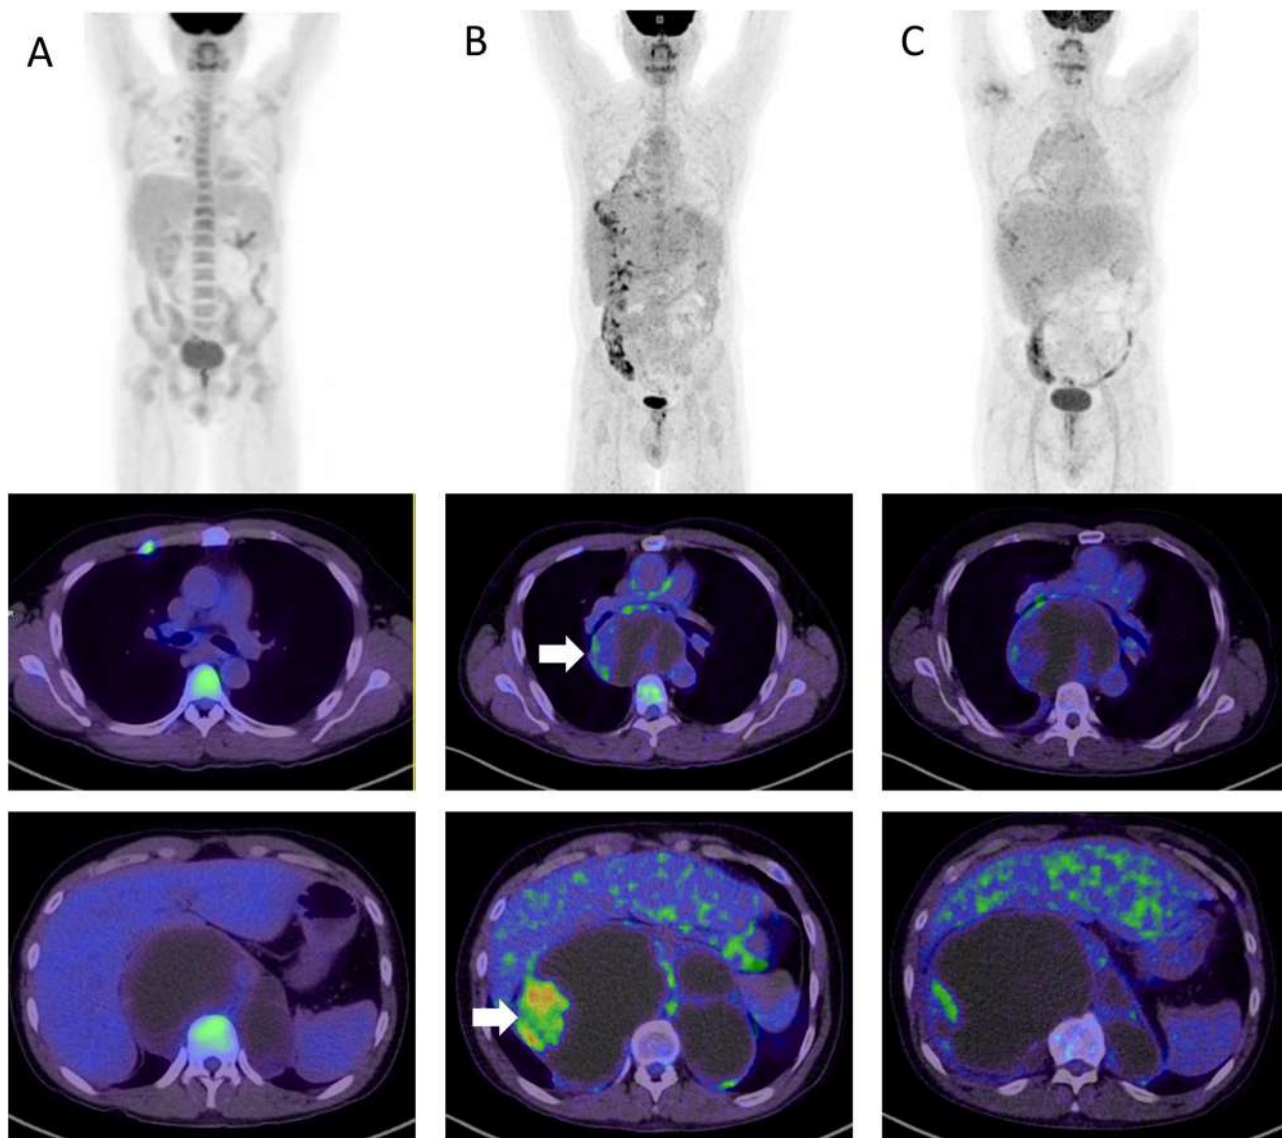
Maximum projection intensity (MIP) in the upper row and ^{18}F -FDG PET/CT fused image in mid and bottom rows. In B, there are mixed retroperitoneal and mediastinal masses (solid and cystic). The retroperitoneal measured 52×47 mm in axial axes with a SUVmax: 14.7 in the solid component, both masses had progression compared to prior study (column A). This solid component (white arrow in B, bottom row) was biopsied. On column C, there is an ^{18}F -FDG PET/CT with partial response after the last chemotherapy cycle in the solid component of the index retroperitoneal mass. Mediastinal, left retroperitoneal and pelvic masses (not shown) remained stable in the three scans and with low FDG-uptake likely related to low-grade tumor (teratoma).
